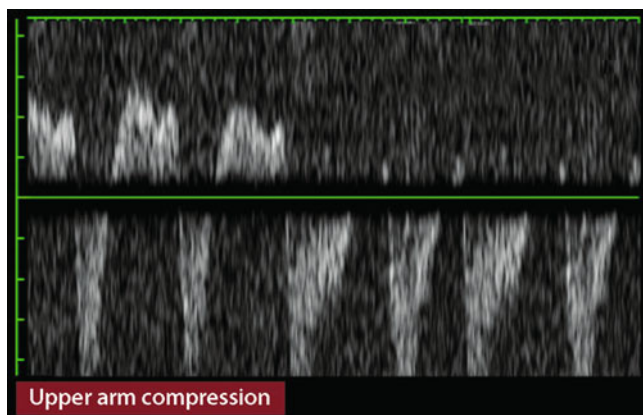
Pulse curves of the vertebral artery with increasing hemodynamic effect of a stenosis or occlusion at the origin of the subclavian artery. If only a Doppler probe is available for diagnosis, the vascular pathology can be assessed with the aid of the Upper Arm Compression Test already described in Sect. 7.5.1. After the end of a 20–30 s lasting upper arm compression, a “worsening” of the pulse curve typically occurs by 1–2 categories to the right due to reactive hyperemia in the arm (Fig. 15.2). Further explanations in the text
